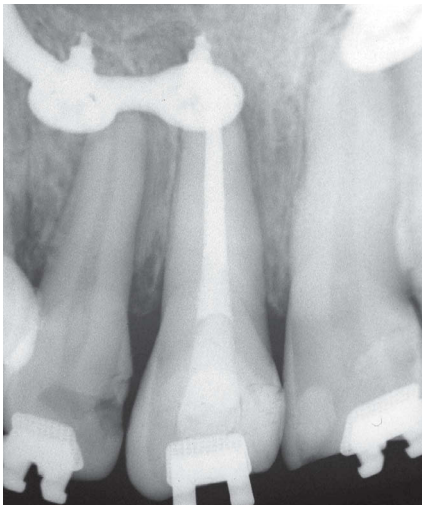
Postoperative periapical radiograph of tooth #21.
